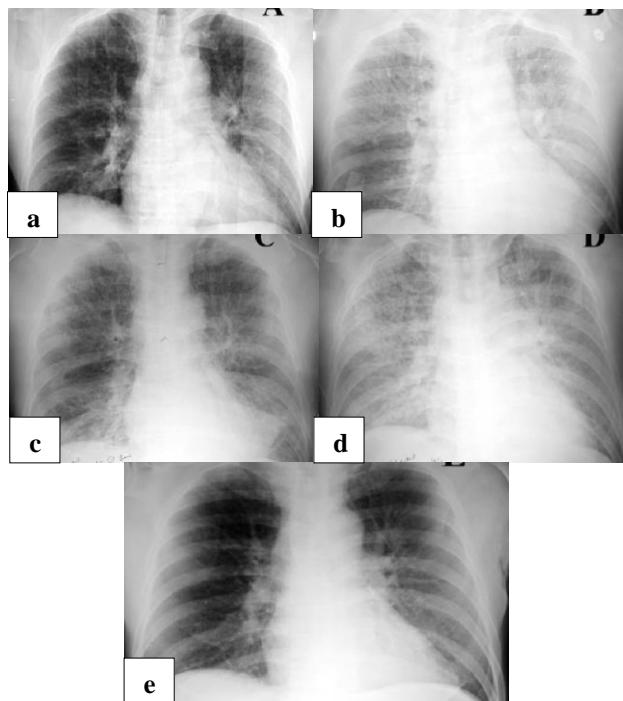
(a-e): Serial supine chest radiographs of a 59-year-old man with a closed fracture of the right femur after falling from a roof.
